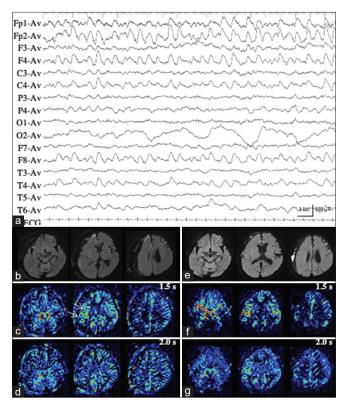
Patient 5. (a) Ictal EEG shows 1.9-Hz rhythmic delta activity with sharp waves in the right anterior quadrant. (b) On diffusion weighted image, the deviation of right cerebral hemisphere is still persistent. However, no parenchymal change has been noted. (c) With PASL at PLD of 1.5 sec, slightly increased area has been observed in the right frontal lobe (white arrows). (d) This finding is not apparent on PASL at PLD of 2.0 s. (e) During interictal state (a month after (a)), DWI reveals slight improvement in the deviation of the right cerebral hemisphere. (f and g) No laterality of ASL signals is observed both on PASLs at PLD of 1.5 (f) and 2.0 s (g). EEG: Electroencephalogram, DWI: Diffusion weighted image, PASL: Pulsed arterial spin labeling, PLD: Post labeling delay.
